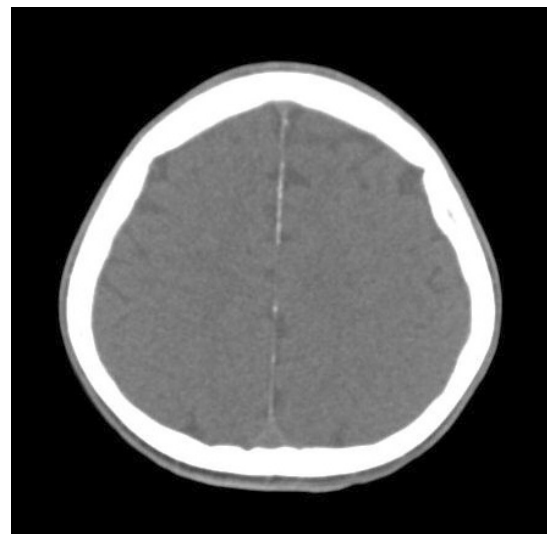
Facial computed tomography view showing calcification of falx cerebri.
